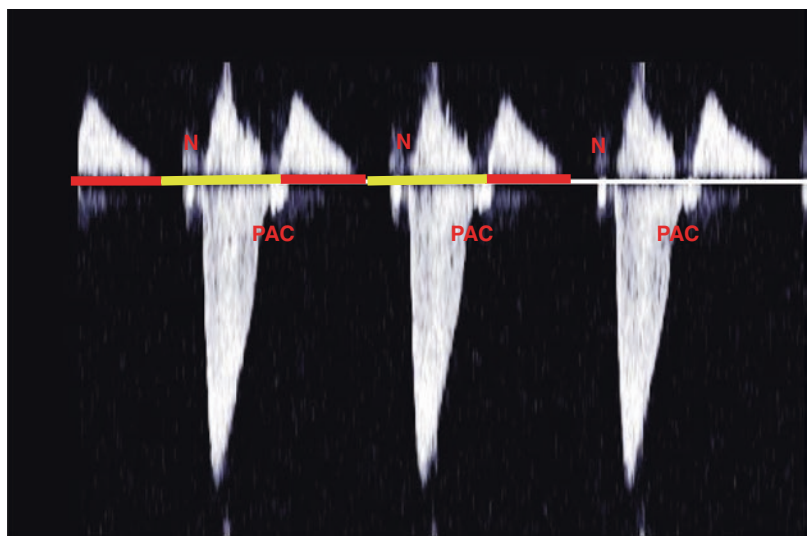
Pulse Doppler of the SVC and aortic outflow showing non-conducted PACs
